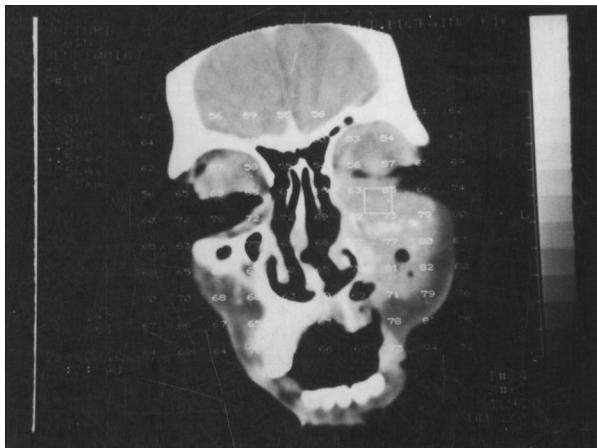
CT scan showing hyperdense mass in left maxillary sinus and thinning of infra orbital margin
